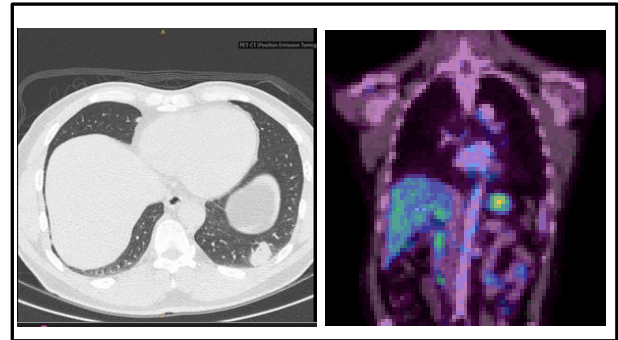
The PET scan revealed a hypermetabolic nodule in the posterobasal segment of the left lower lobe lung, measuring 2.6 x 2.2 cm with an SUVmax of 5.8.
